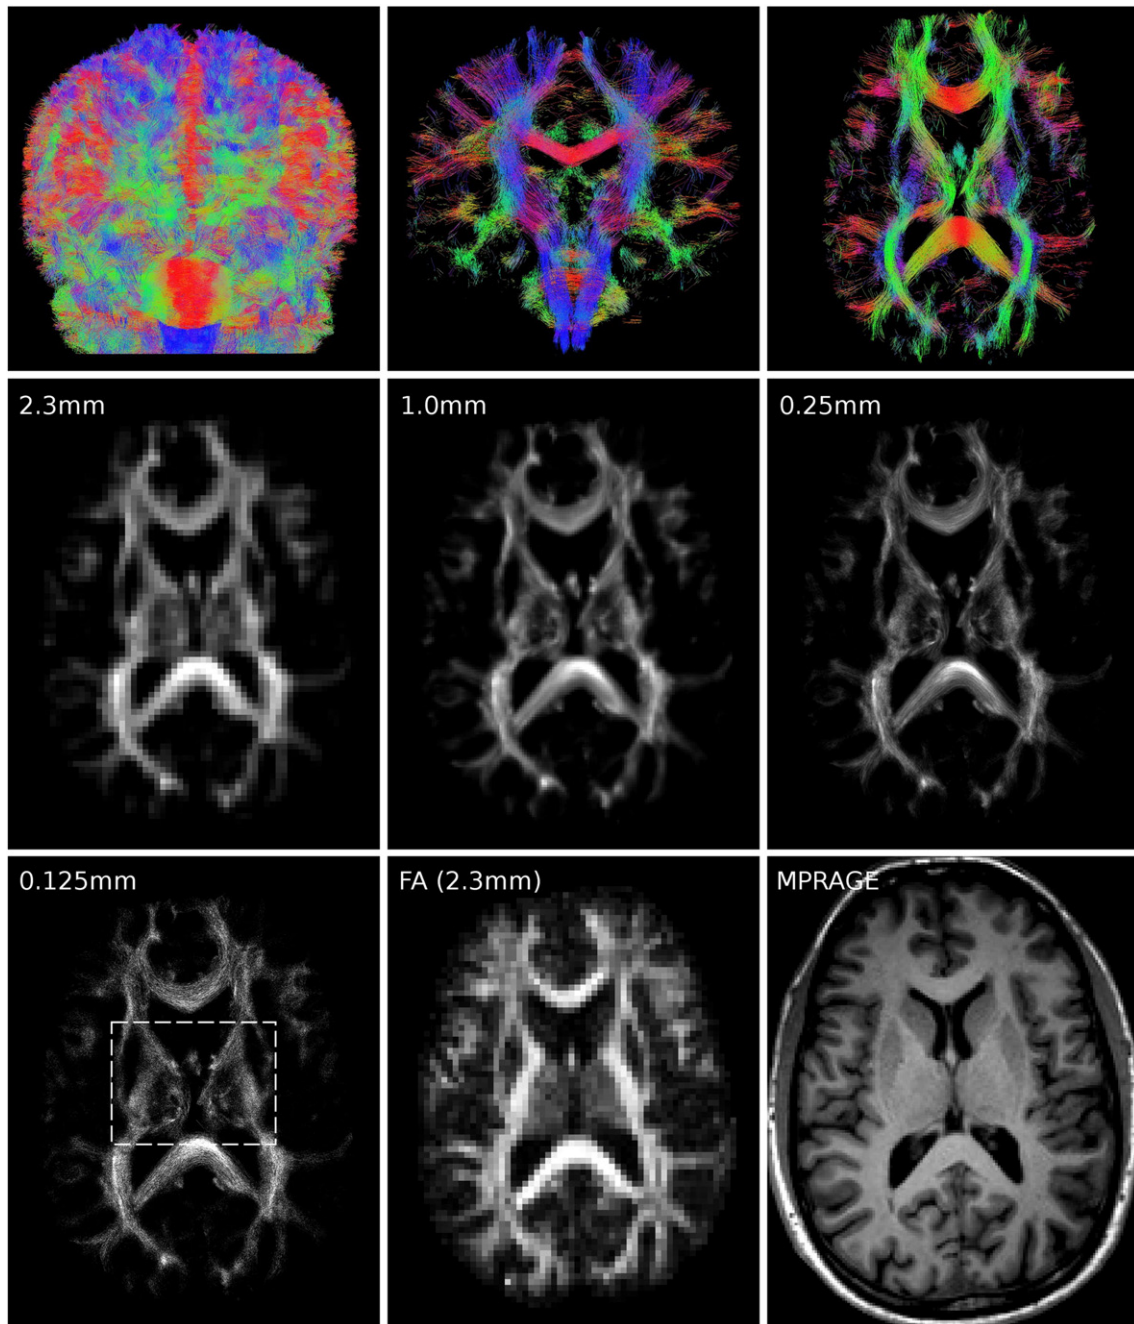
Super-resolution properties of the TDI technique. Top row: whole-brain probabilistic fiber-tracking results generated from the original (low resolution) DWI data: (top-left) front-view of whole-brain; (top-middle) 2-mm coronal slab; (top-right) 2-mm axial slab. For display purposes, only 100,000 tracks are shown. The color-coding indicates the local orientation (red: left-right, green: anterior–posterior, and blue: inferior–superior). Middle row and bottom left: axial whole-brain track-density maps generated for subject *S1* with increasing spatial resolution, i.e. with decreasing grid-size: isotropic grids of 2.3 mm (the original source resolution for this subject), 1.0 mm, 250 μm and 125 μm ; all TDI maps were created using 2,500,000 tracks. For comparison, FA map and the anatomical 3D T1-weighted image (MPRAGE) are also shown for the same slice locations (bottom row). The dashed region in the bottom left image shows the zoomed-area displayed in Fig. 2. To facilitate visual comparison, the TDI maps were windowed differently: the [minimum–maximum] TDI intensity range was: [0–3759] for the 2.3 mm resolution, [0–916] for the 1 mm, [0–109] for the 250 μm , and [0–34] for the 125 μm ; as expected, the intensity decreases with increasing resolution (for a fixed total number of tracks).
